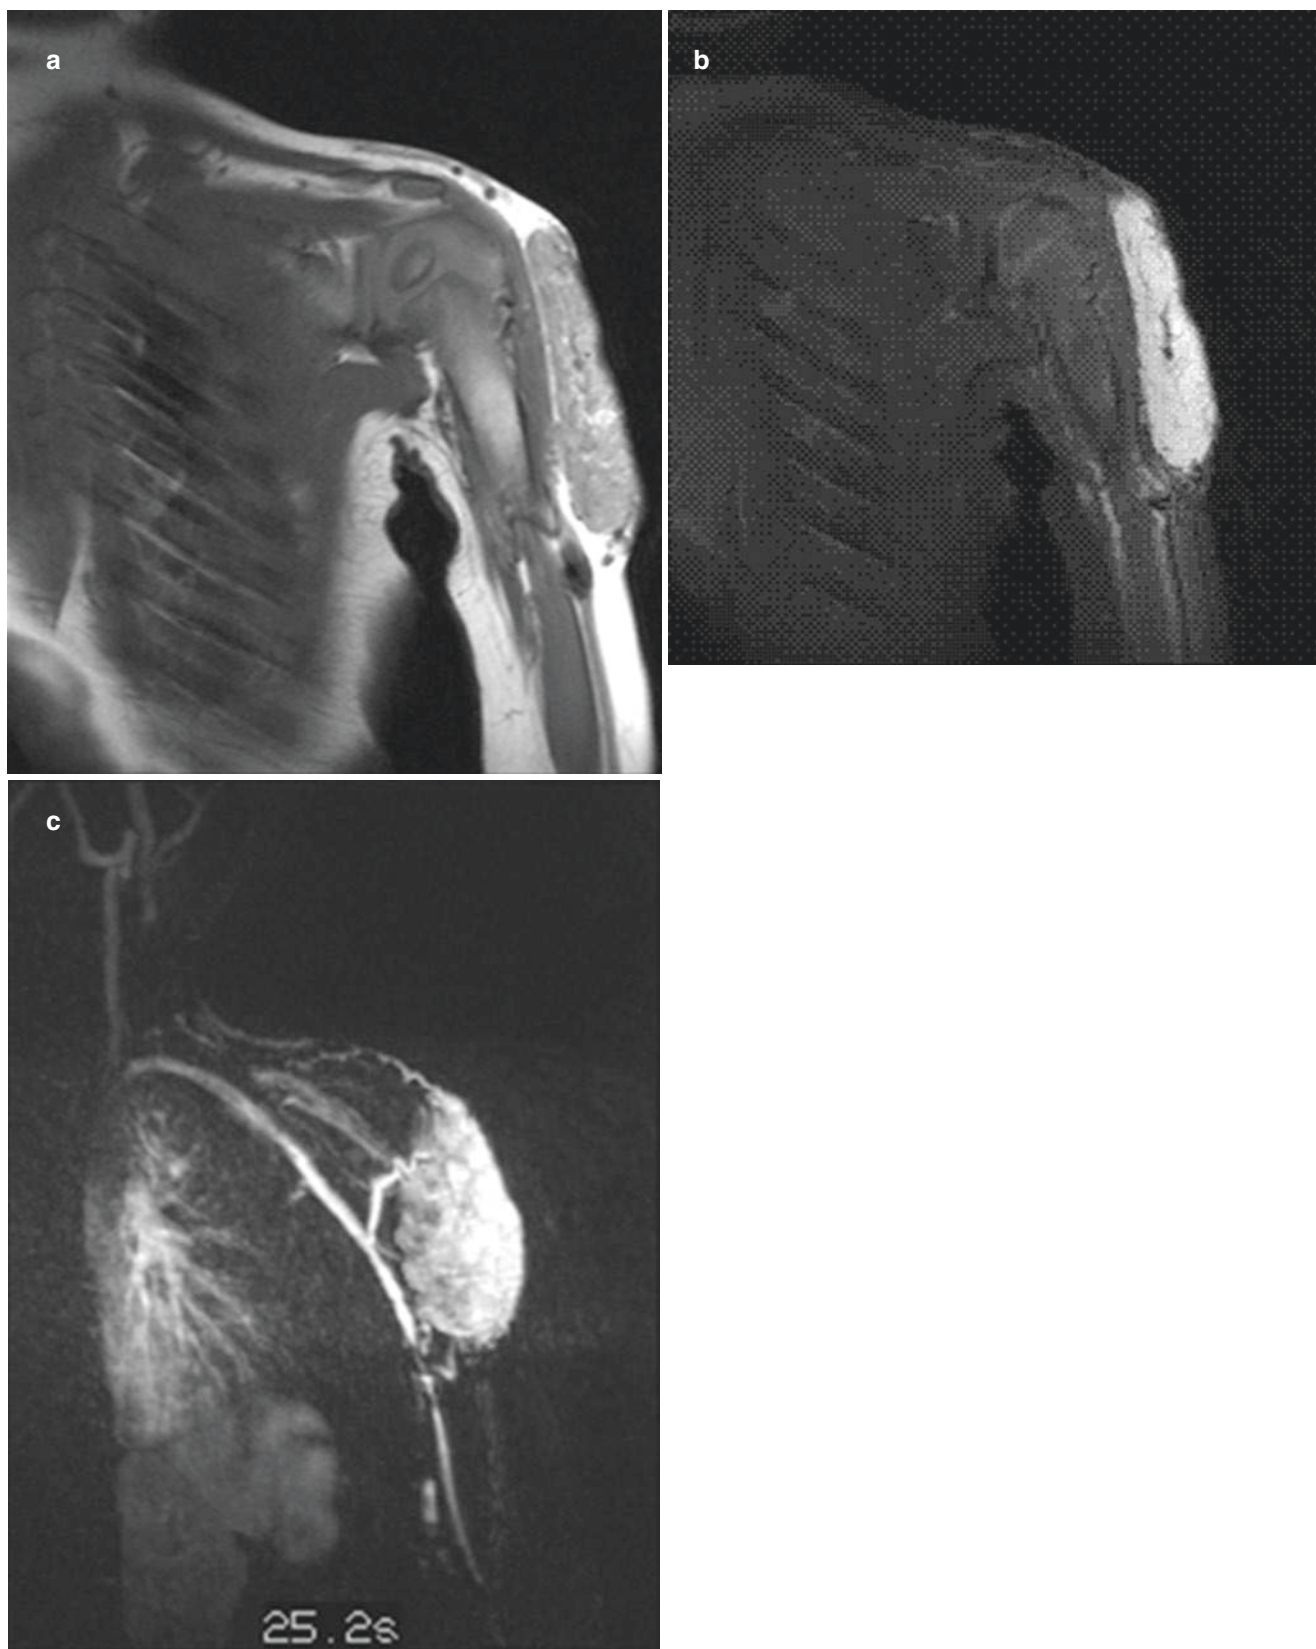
Infantile hemangioma. 10-month old boy with an enlarging mass on the proximal left arm. (a) Coronal T1-weighted image shows a lobulated, relatively well-defined mass in the superficial soft tissues of the proximal arm. There is a vessel with a flow void inferior to the mass indicating a fast-flowing vessel. (b) Gadolinium-enhanced
